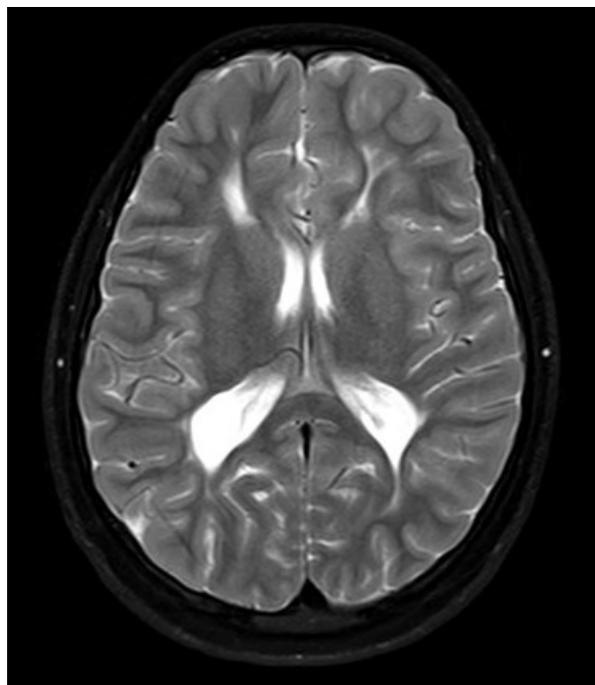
Periventricular leukomalacia - MRI showing posterior ventricular hyperintensities and squaring of ventricles
